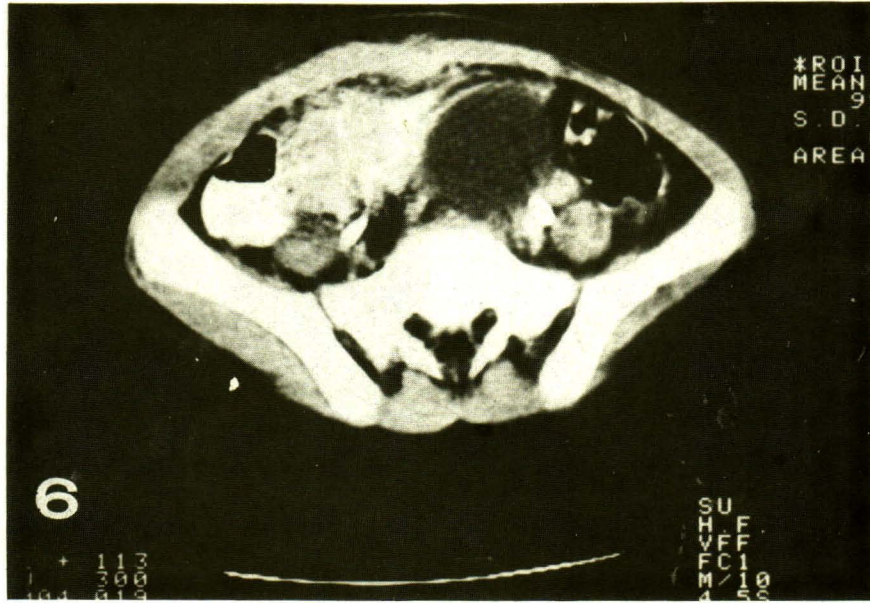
CT scan showed homogeneously enhanced soft tissue mass at the ileocecal area and narrowing of terminal ileal lumen, with extension to adjacent anterior abdominal wall (Case 2).
